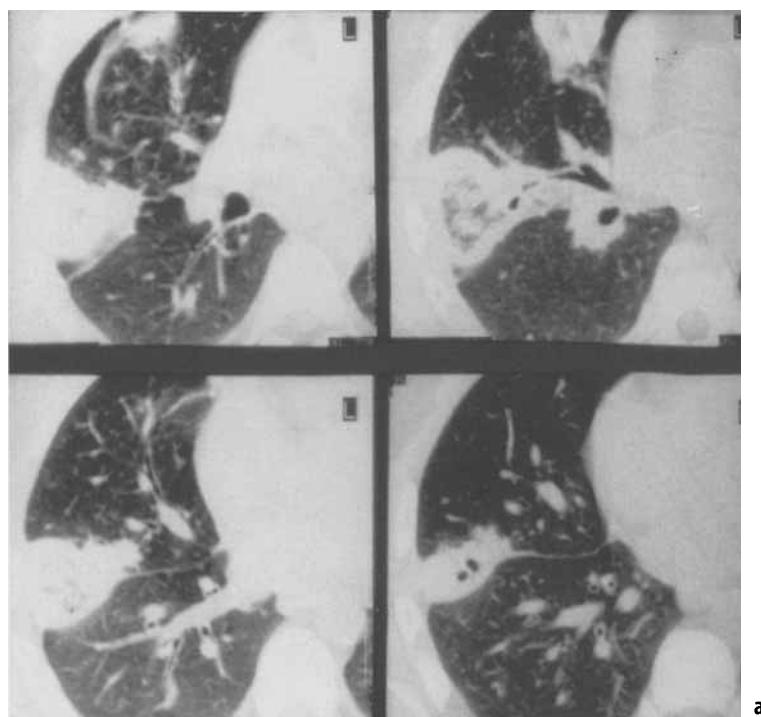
a, b, c. Invasive aspergillosis in leukemic patient, with triangular-shaped consolidation in the early stage of the disease. An initial central cavitation is well depicted by HRCT (a). A large fungine lesion, surrounded by a peripheral 'ground-glass' (halo sign) and distal air-bronchogram is detected by HRCT in the lower right lobe (b). Invasive aspergillosis in a leukemic patient, with restoration of granulocyte function, shows the 'air-crescent sign' due to the interposition of air between the infarcted lung tissue and the adjacent healthy parenchyma (c). (Figure 11.2b, c continued overleaf.)
